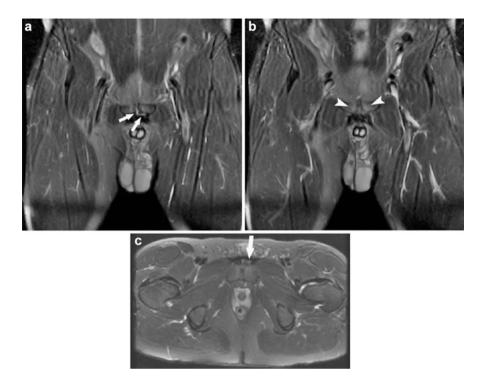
Thirty-eight-year-old man with left groin pain, osteitis pubis, and avulsion of adductor longus. (a) Coronal fat suppressed T2 weighted image of the pelvis shows a linear cleft of high T2 signal (*white arrows*) indicating a tear of the adductor tendon origin. (b) Coronal fat suppressed T2-weighted image of the pelvis shows bone marrow edema (*white arrowheads*) in the pubic symphysis indicating osteitis pubis. (c) Axial fat suppressed T2 weighted image of the pelvis shows high signal (*white arrow*) replacing normal black in the left adductor longus origin indicating a tear
